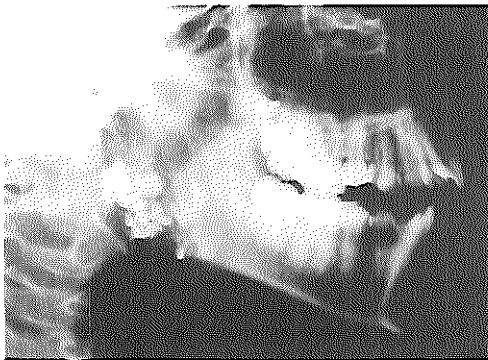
Lateral X-ray view of the parotid region. Sialographic examination in the same patient as fig. 3a. The cystic dilatations of the ductal system are filled with contrast medium.*
